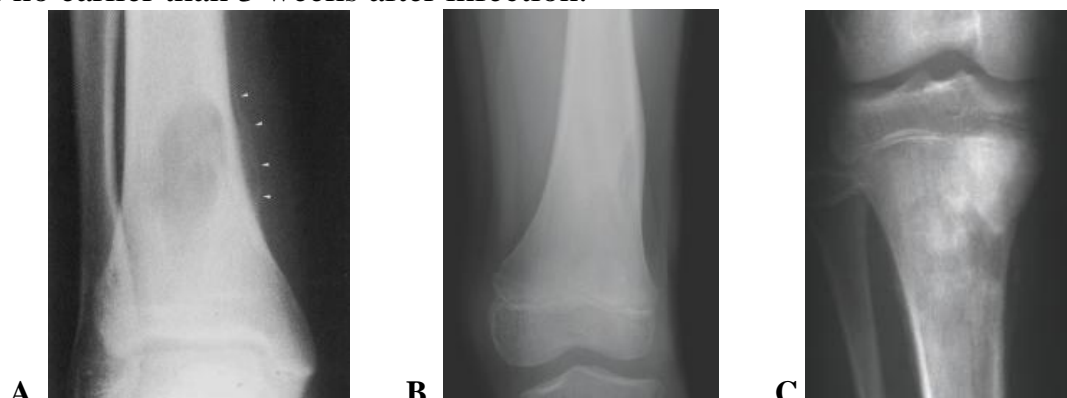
Frontal radiographs of leg. (A) Osteomyelitis (i.e. Brodie's abscess). Magnified radiograph of the right ankle showing a large lytic tibial lesion. Notice the periosteal reaction medial to the tibia (arrow heads). (B) Radiograph of the distal thigh showing a lytic lesion of medial area of femur at early osteomyelitis. (C) Chronic osteomyelitis of proximal tibia.
